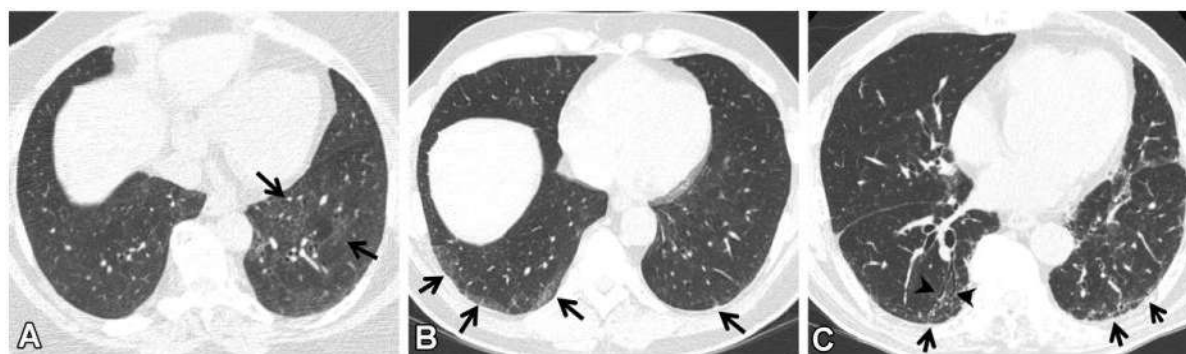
Subcategories of ILA on axial CT images
